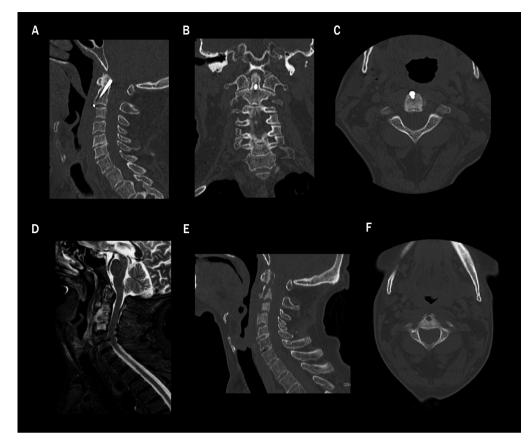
A. Postoperative sagittal CT – proper position of screw fixation; B. Postoperative coronal CT; C. Postoperative transversal CT; D. Postoperative saggital MRI – fistula canal in posterior pharynx extends into the larynx. Diffuse inflammatory of C2-C4 infiltrates into intervertebral discs; E. Postoperative sagittal CT – after screw extrusion. Fracture fissure with signs of osteolysis; F. Postoperative transversal CT
